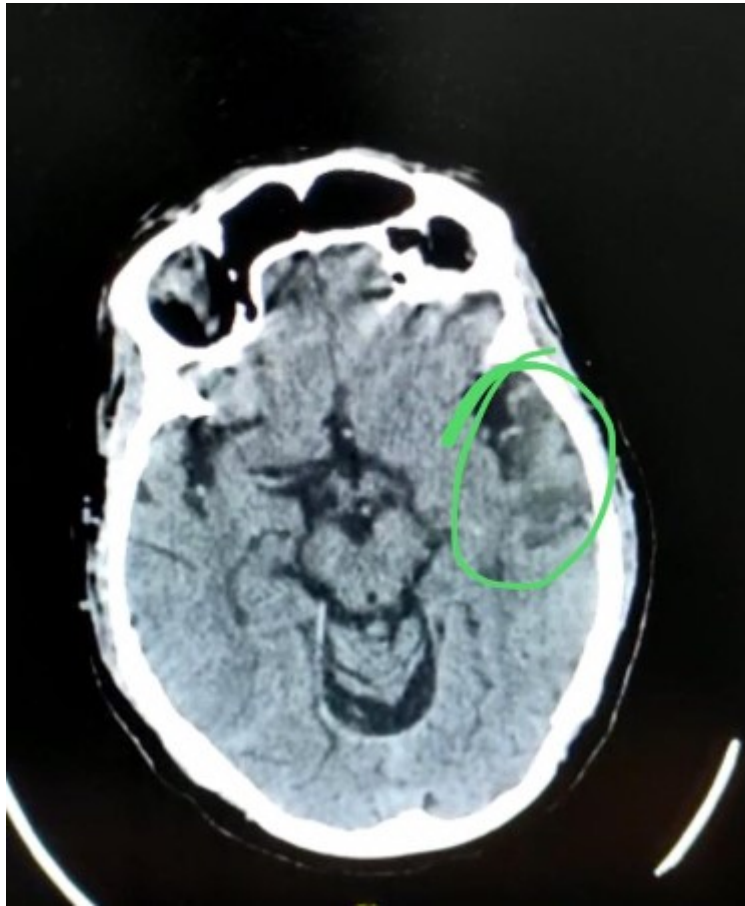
A slice of the CT images of the head demonstrating left middle cerebral artery infarction in temporal region
